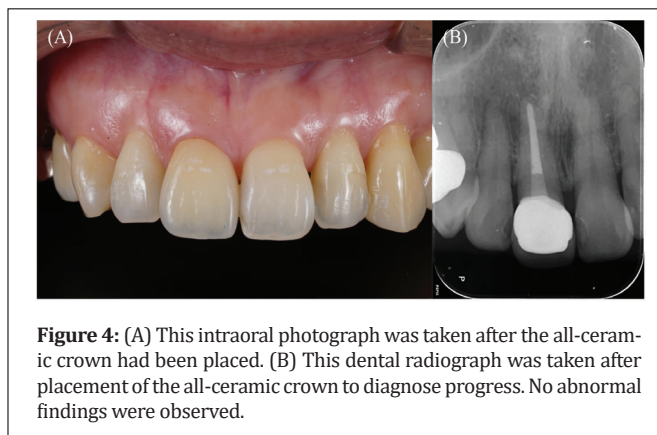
(A) This intraoral photograph was taken after the all-ceramic crown had been placed. (B) This dental radiograph was taken after placement of the all-ceramic crown to diagnose progress. No abnormal findings were observed.
